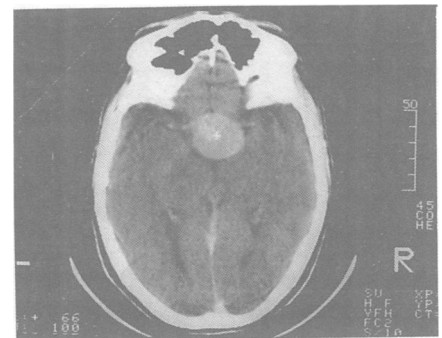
Figure CT scan showing sellar and suprasellar hyperdense lesion.
